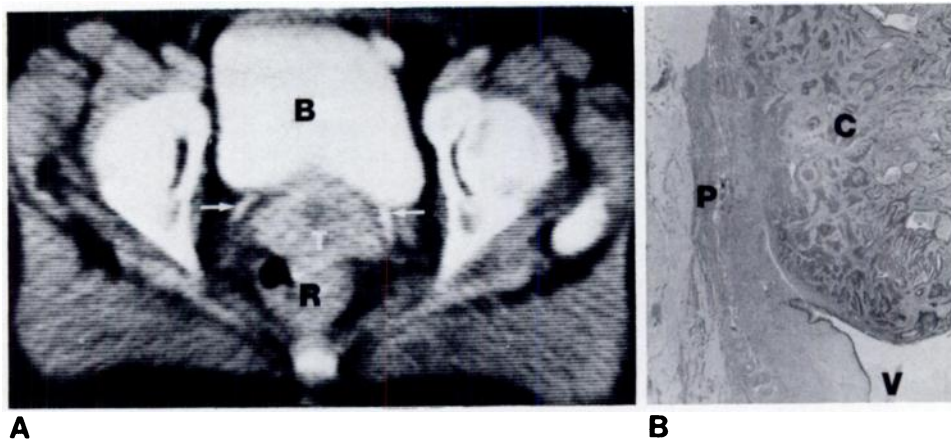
Stage IIB cervix carcinoma. CT scan through bladder (B) and rectum (R). Cervix tumor (T) with soft tissue mass extension into right parametrium (arrows).
